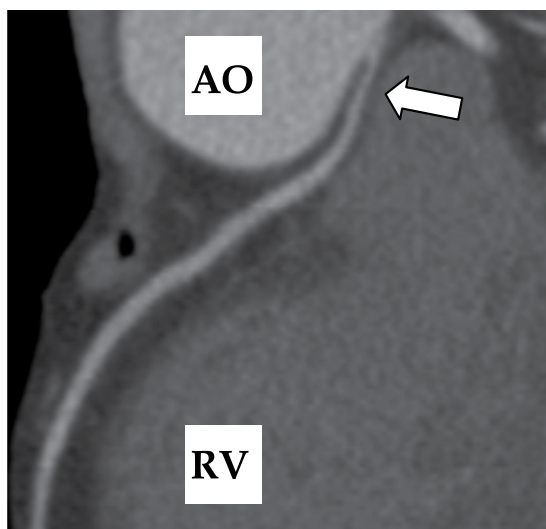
Multiplanar reconstruction of computed tomography showing an hypoplasia of the initial path (arrow) of a right coronary artery arising from the left sinus. AO: aorta, RV: right ventricle.
